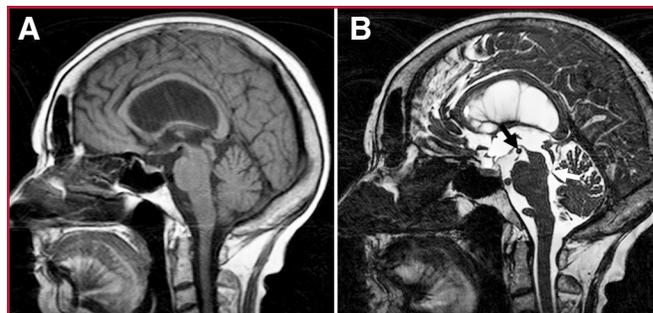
Imaging was performed for aqueductal stenosis. A, mid-sagittal noncontrast T1-weighted magnetic resonance imaging (MRI) scan showing enlarged lateral ventricle and bowing of the corpus callosum and normal-sized fourth ventricle. The cerebral aqueduct appears patent. B, corresponding constructive interference in steady state (CISS) MRI scan reveals a distal cerebral aqueduct occlusive membrane (white arrow). The premesencephalic cistern has favorable anatomy, with a posteriorly placed basilar artery bifurcation (black arrow), for endoscopic third ventriculostomy (ETV).
